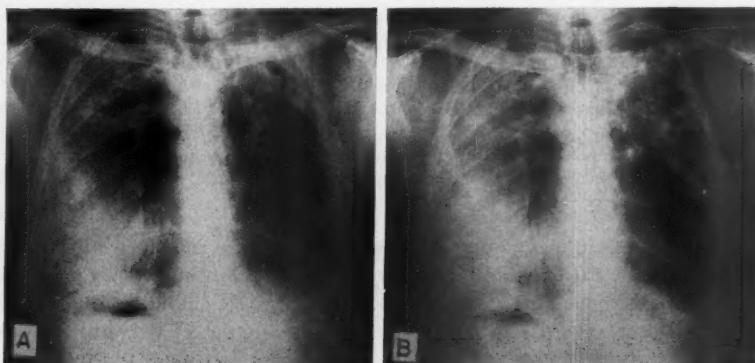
Case 1. G. B. Roentgenogram showing cavitation in apical portion of right lung and bilateral pleural thickening.
